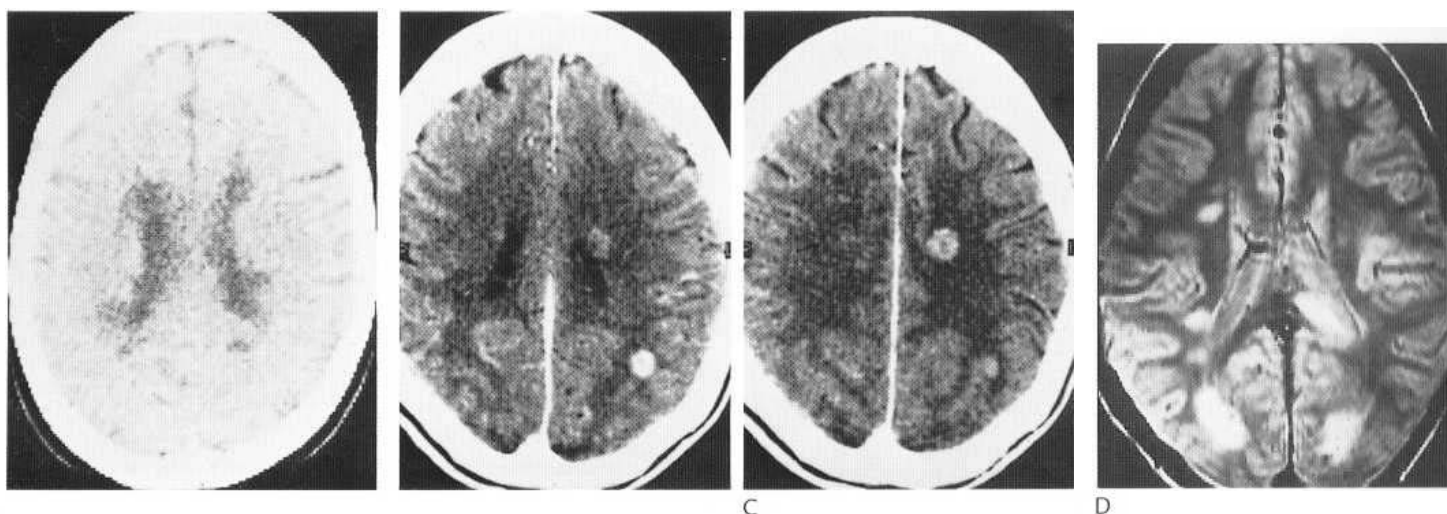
Multiple sclerosis. (A) Paraventricular and white-matter low-density areas. (B,C) Enhancing paraventricular and white-matter low-density areas. (D) Axial MRI section J, -weighted). Multiple sclerosis plaques are seen as areas of high signal.
